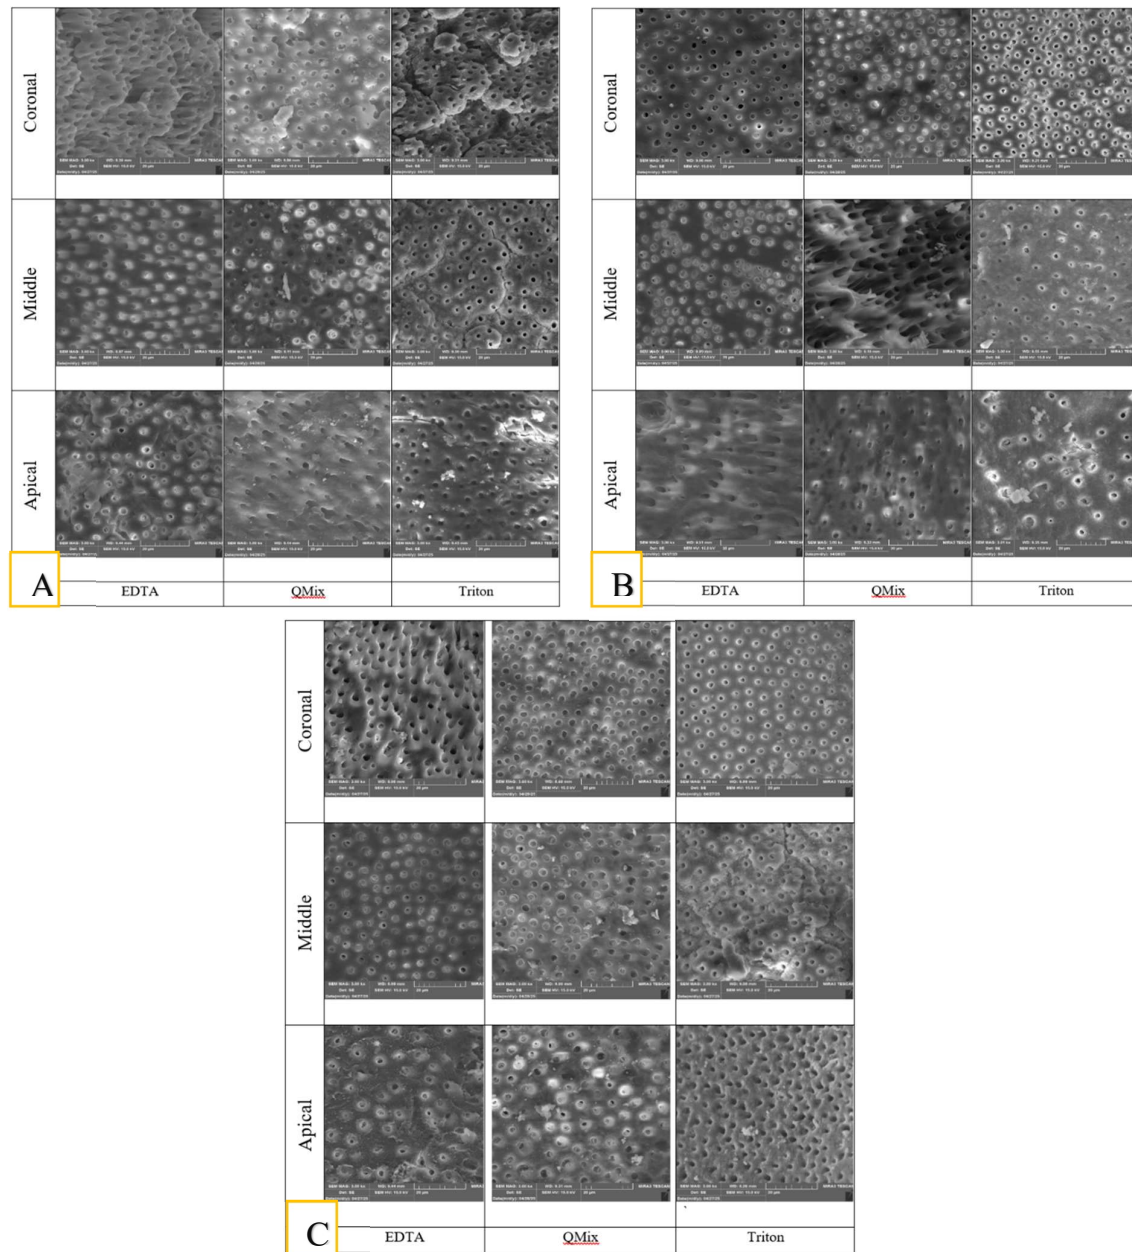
SEM images of smear layer removal from the root canal walls in each group and root third (magnification x3000) (A. Diode laser B. Sonic, C. Ultrasonic).
